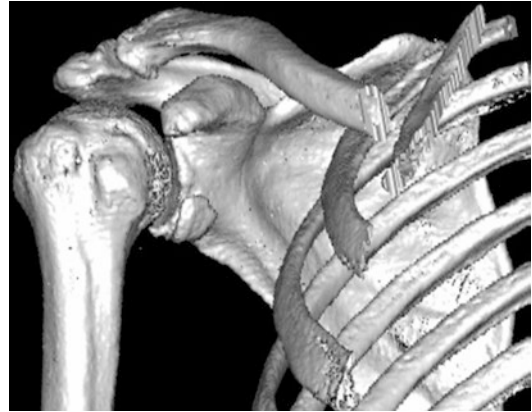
3D-CT reconstruction 1
